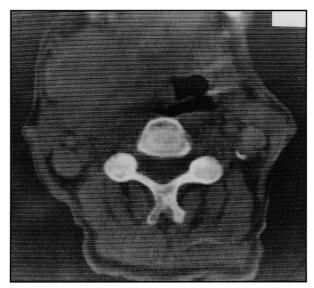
Computed tomography scan of neck showing submandibular mass.
